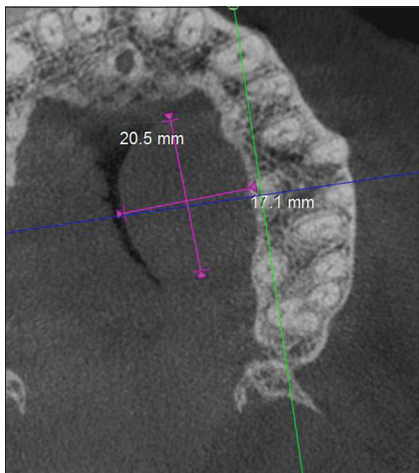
Cone-beam computerized tomography image
